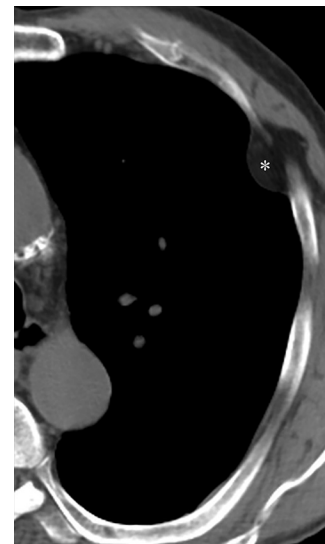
Lipoma mimicking focal thickening of the EPS. Axial cropped CT image shows an intercostal lipoma (*) in the EPS.
